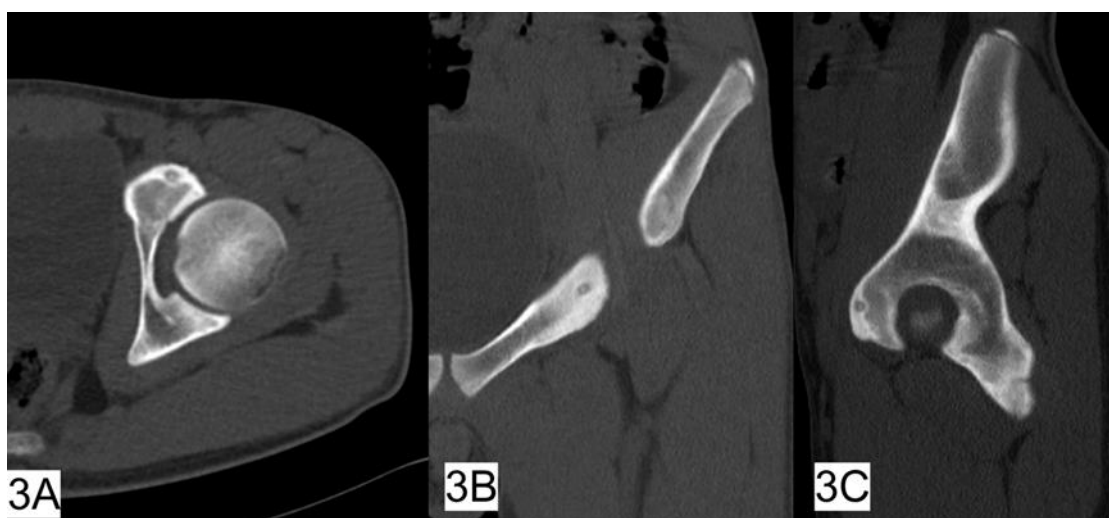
A - Case no. 15, osteoid osteoma of the pubic ramus, CT scan transversal section. B - Case no. 15, osteoid osteoma of the pubic ramus, CT scan frontal section. C - Case no. 15, osteoid osteoma of the pubic ramus, CT scan sagittal section.
